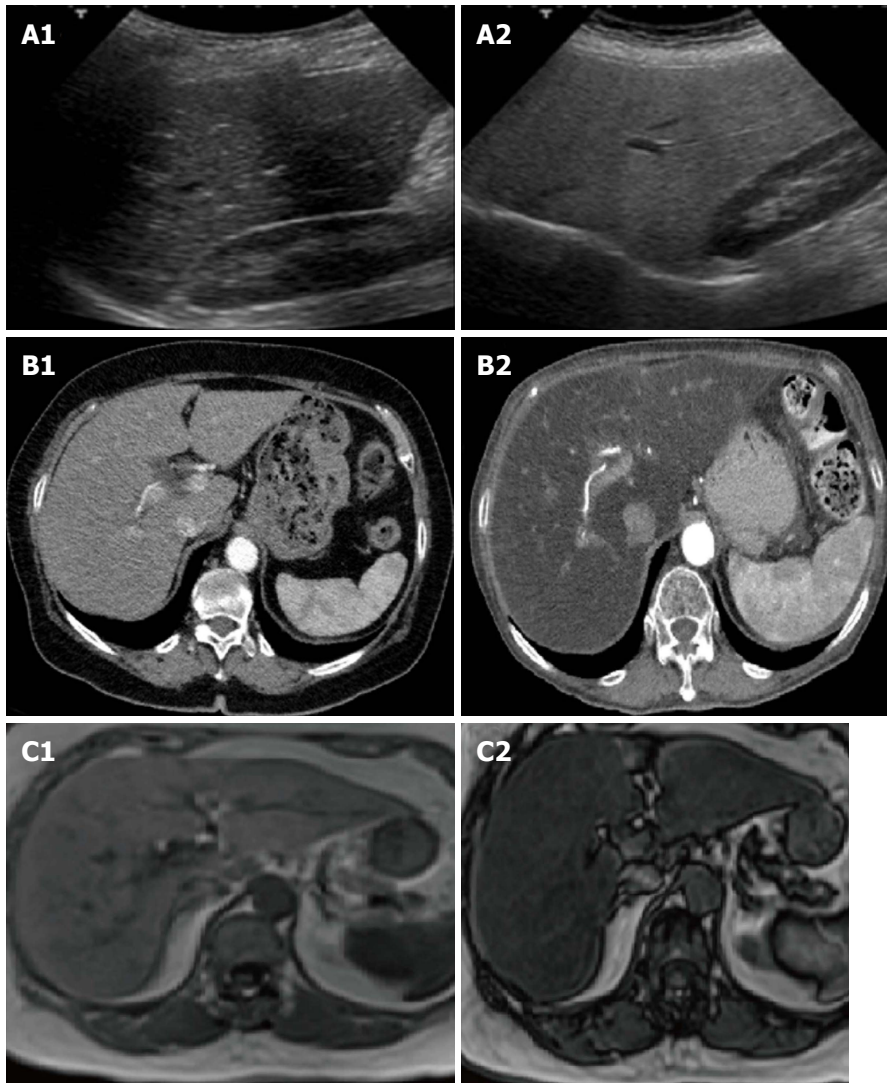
Aspects of liver steatosis according to the different imaging techniques. In normal ultrasound examination liver parenchyma is isoechoic to the renal parenchyma in normal conditions (A1), becoming hyperechoic in presence of liver steatosis (A2). In comparison to a normal liver (B1), a fatty liver appears hypodense compared to the spleen and to the hepatic veins (B2) in computed tomography scans. Finally, in the setting of a severe steatosis, the magnetic resonance signal has a clear fall from in phase (C1) to out phase sequencings (C2).
